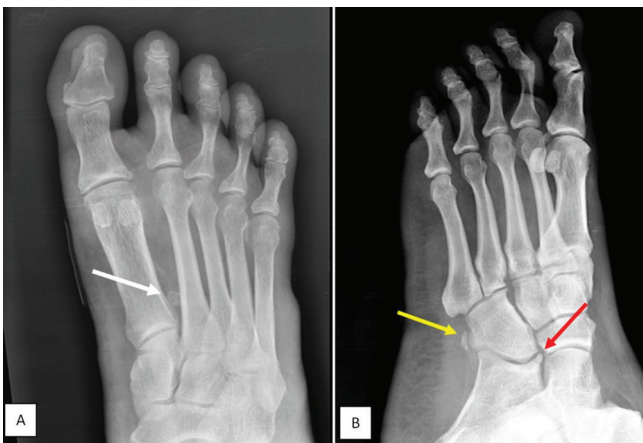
(A) AP view in foot radiograph showing first interphalangeal sesamoid bone (white arrow), (B)Oblique view of foot showing os peroneum(yellow arrow) and os calcaneus secundarius(red arrow). Technique- 50-55 kVp and 3 mAs in a 500 mA Allengers MARS 50+ x-ray machine
